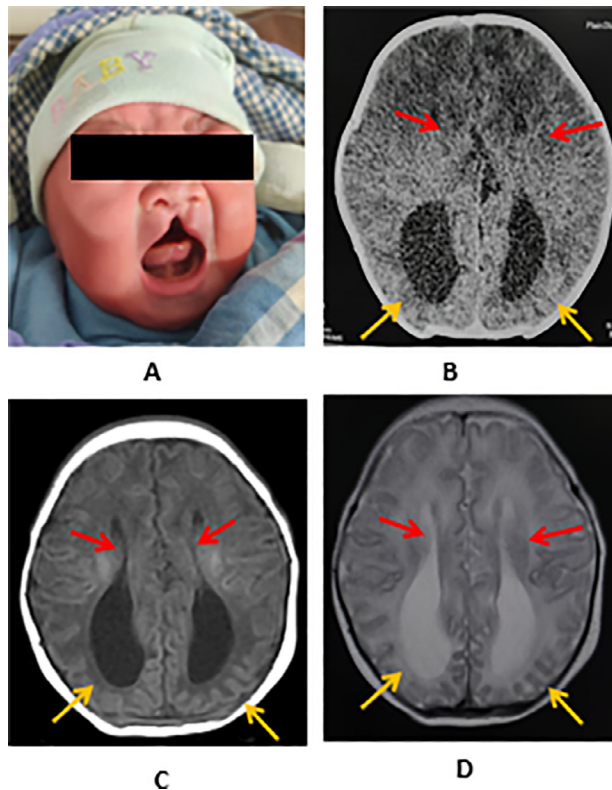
(A) Patient with a cleft lip. (B) Axial computed tomography and (C, D) Axial T-1 and T-2 weighted magnetic resonance imaging of the brain show non-converging lateral ventricles (red-arrows) with disproportionately enlarged occipital horns suggestive of colpocephaly (yellow-arrows) (color version of figure is available online.)
